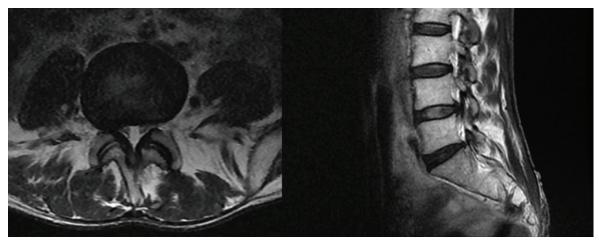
MRI of lumbar spine before transforaminal injection MRI: Magnetic resonance imaging
